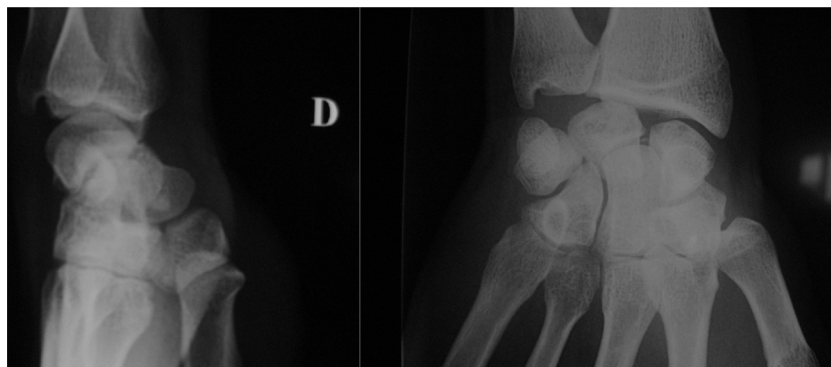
Standard preoperative A/P and lateral radiographs of the right wrist.
